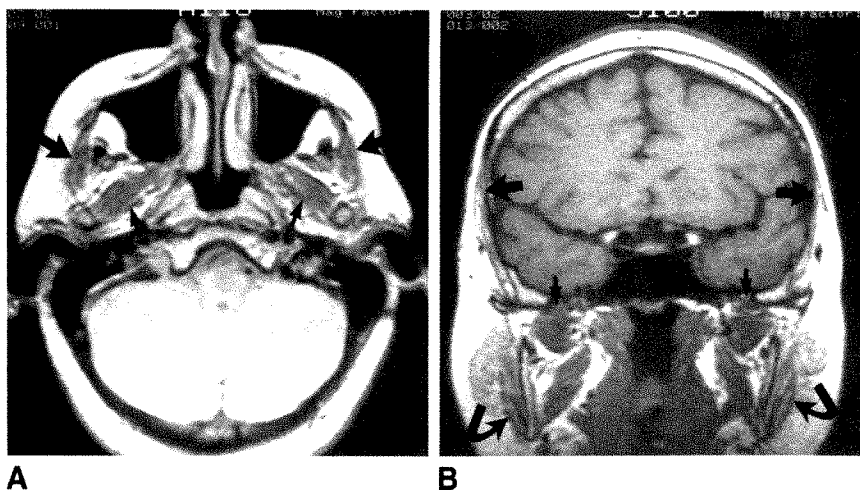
A and B, Muscle atrophy caused by myasthenia gravis in 49-year-old woman with masticatory muscle weakness and wasting scanned for suspected brainstem disease. Axial (A), 2000/20, and coronal (B), 800/20, MR images reveal severe atrophy affecting the temporalis (*large straight arrows*) and masseters (*curved arrows*). Lateral pterygoids (*small arrows*) are moderately atrophic. Myasthenia gravis was diagnosed after muscle atrophy was noted and brainstem disease ruled out.
